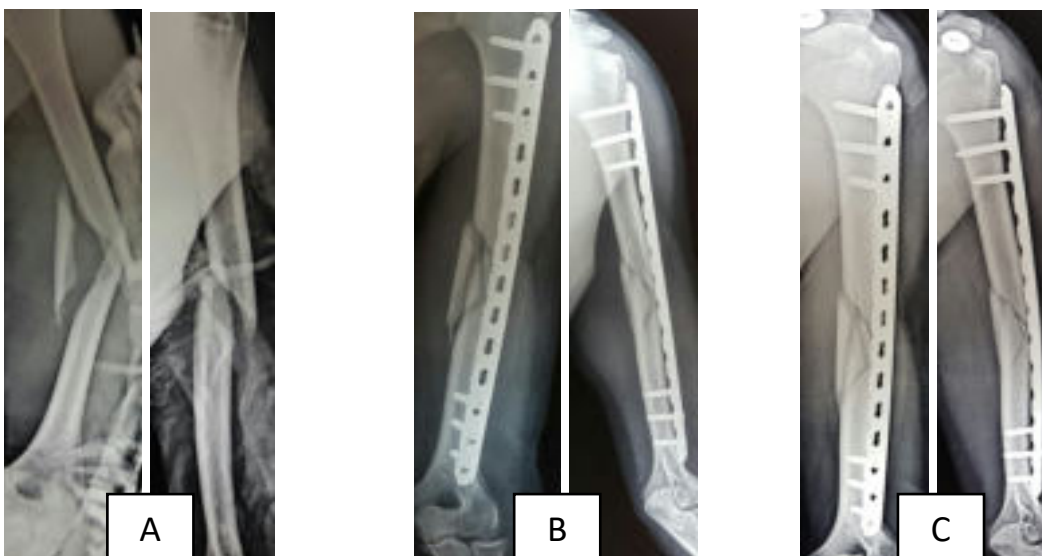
24 year male fracture left humerus A-O type 12 B.3 Bridge plating with Locking Compression plate. (A) Pre-operative x-ray. (B) immediate post-operative x-ray. (C) 3 month post-operative x-ray.
